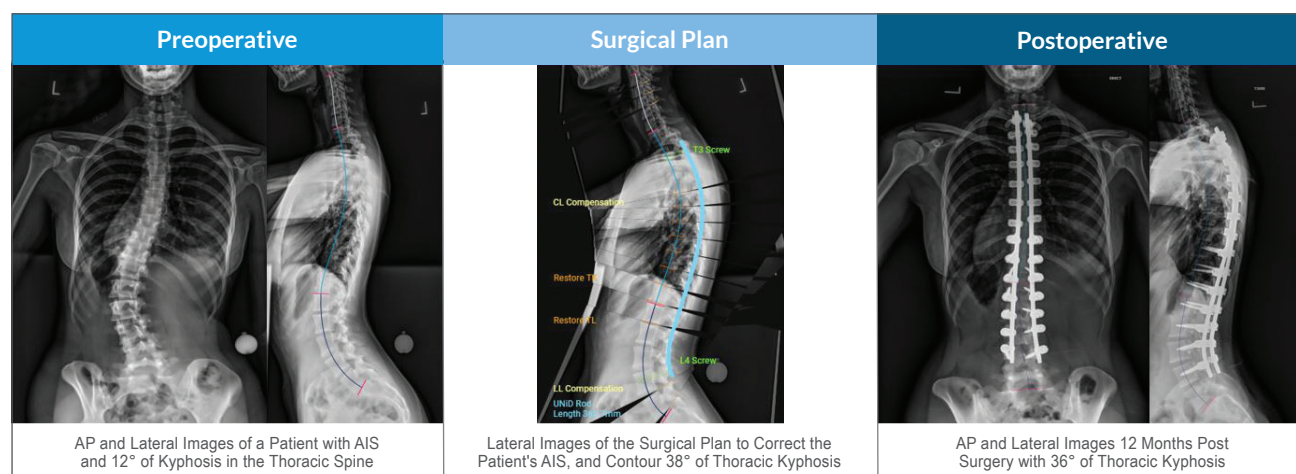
Preoperative, surgical plan, and postoperative radiographic images of patient with AIS and thoracic kyphosis
